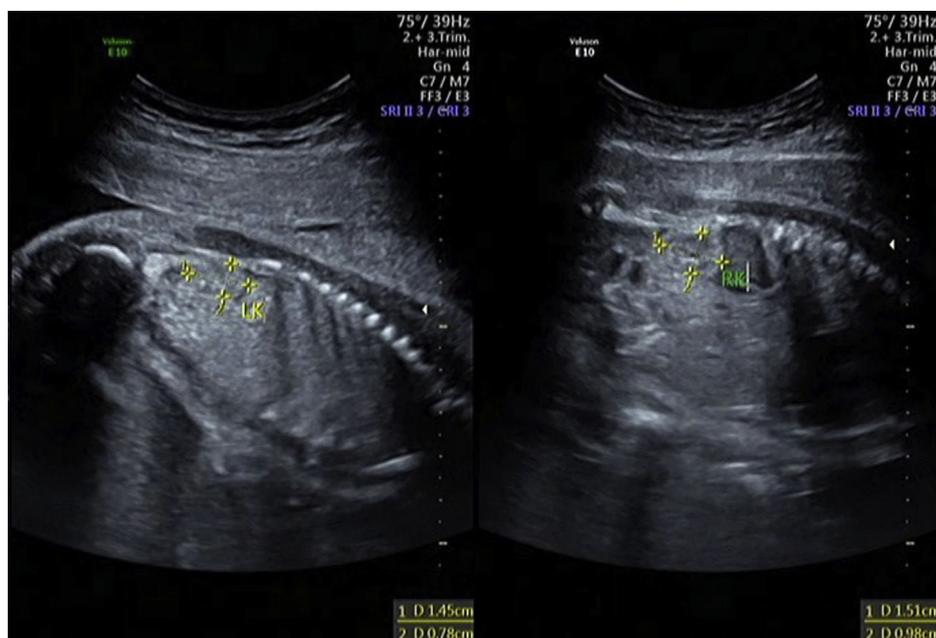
Sonographic image of the fetus at 25⁺⁵ weeks of gestation showing bilateral small kidneys (left: 1.52 cm × 0.72 cm, right: 1.51 cm × 0.98 cm).
